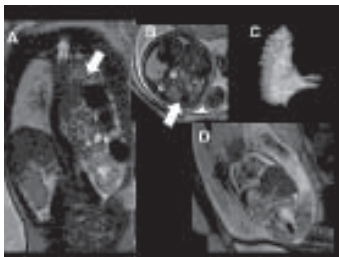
A-D, Fetal MRI of Thorax. A, B, C Congenital diaphragmatic hernia indicated by right hemithorax occupied by bowel loops, some fluid-filled. The right lung is markedly compressed and is seen as
